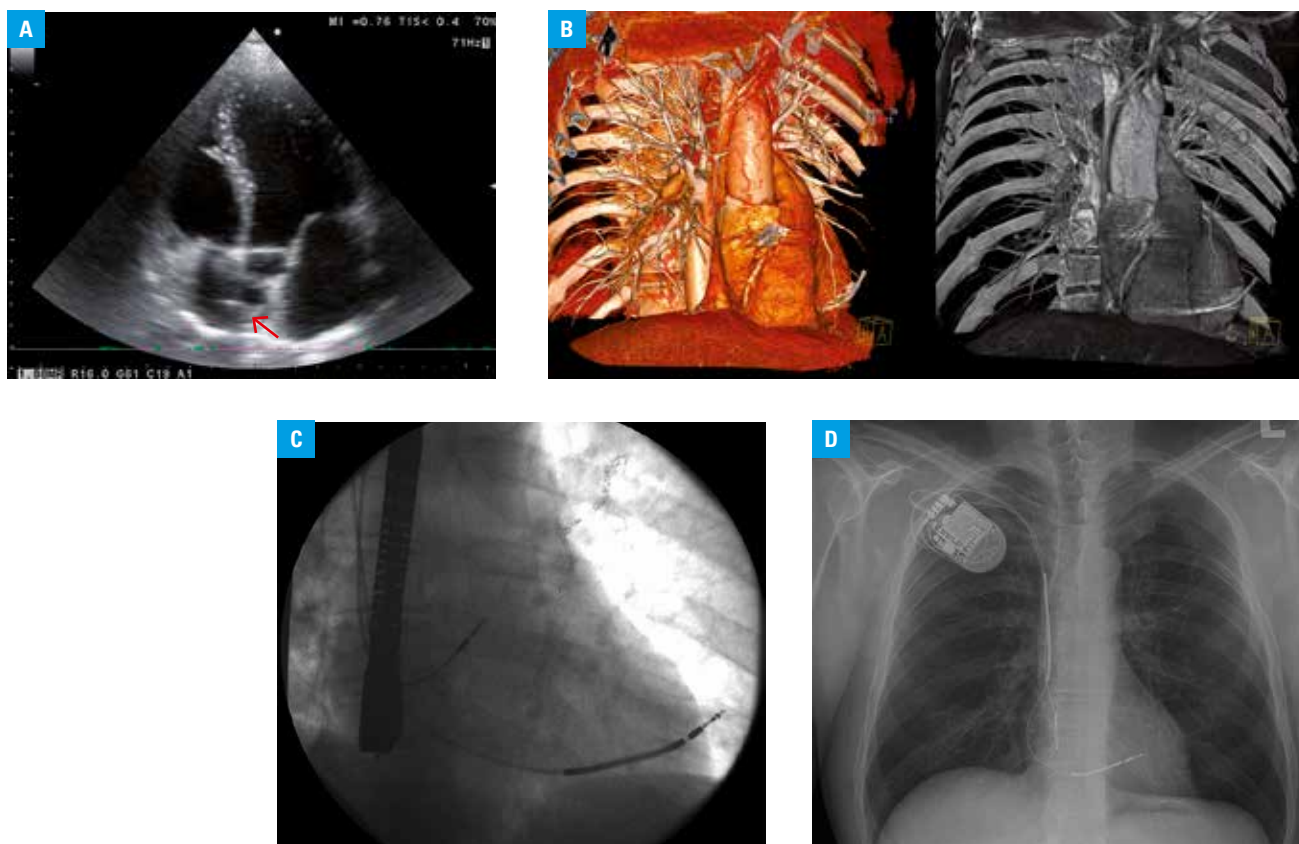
A – transthoracic echocardiogram: vegetation in the right atrium (arrow); B – ventricular perforation; C – intraoperative X-ray imaging; perforation and a transesophageal echocardiogram probe; D – an X-ray image of the implantable cardioverter-defibrillator on the right side
